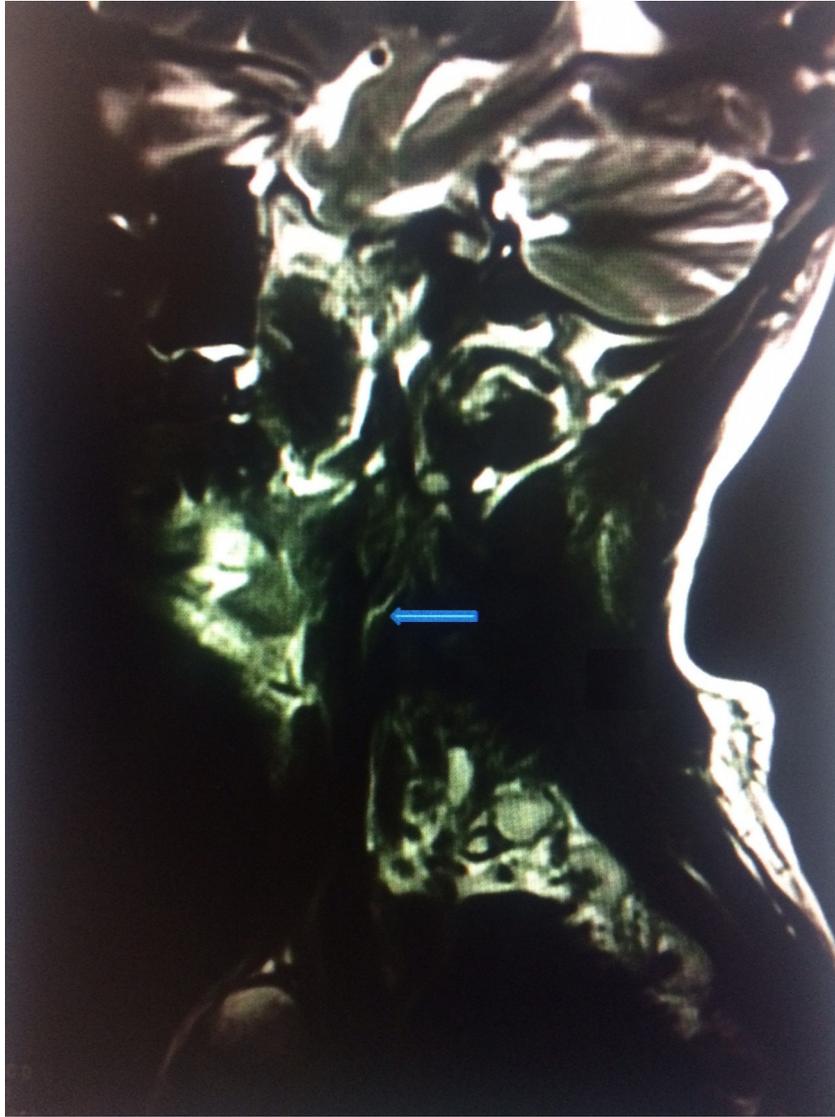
Arrow showing nerve between carotids in MRI scan.
